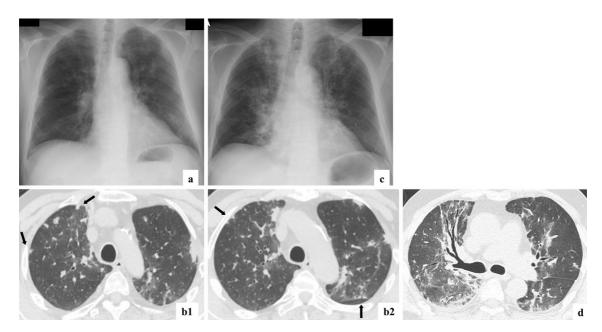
Chest imaging findings of case 1. Chest X-ray on admission showed nodules in the bilateral lung fields (a). Computed tomography showed diffuse bronchial wall thickening and bilateral small nodules that existed along the airways, but some nodules were randomly distributed (arrows) (b1, 2). Chest X-ray performed on hospital day 10 showed increased bilateral shadows (c). Computed tomography on hospital day 10 showed bilateral consolidations and shrinkage change with broncho-dilation and distortion (d).
